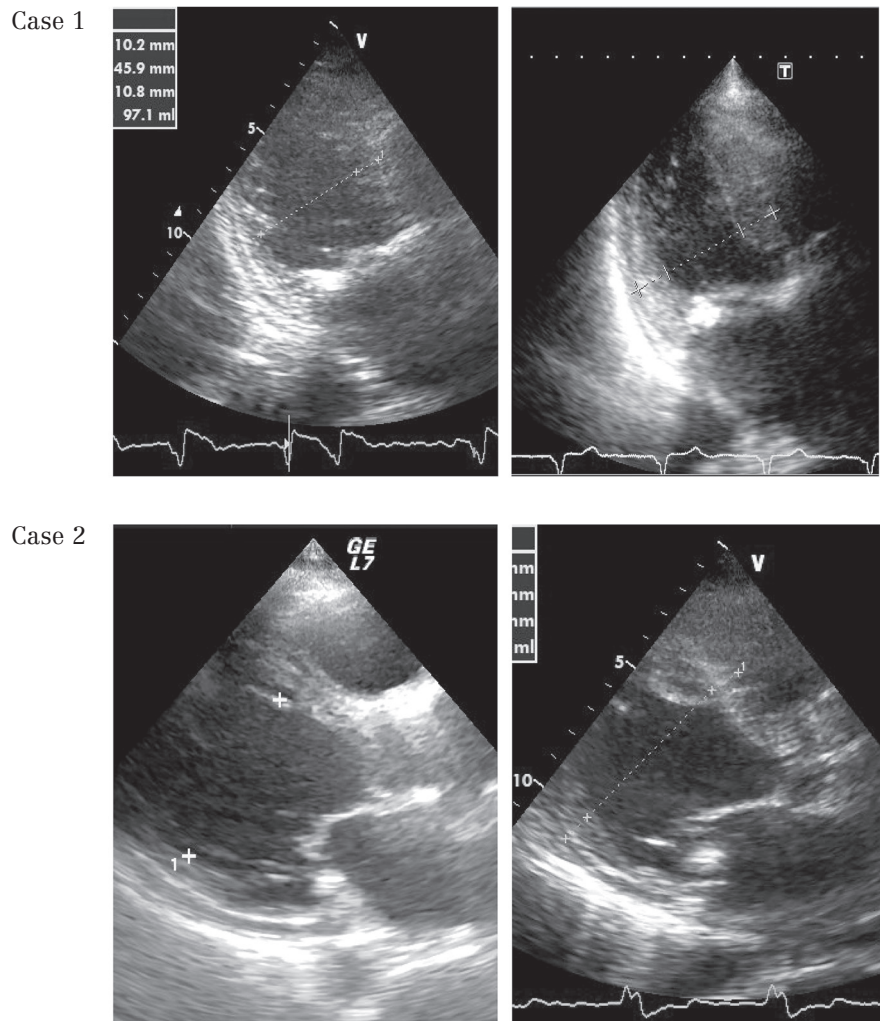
Echocardiograms of both cases examined at baseline (left) and during the follow-up period (right).
